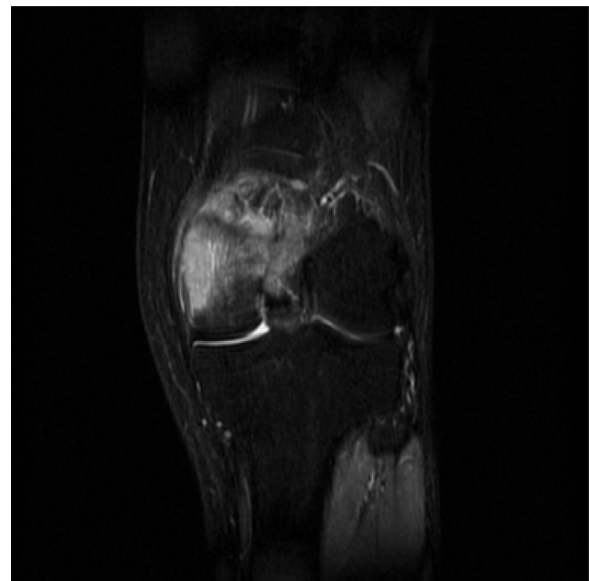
The first MRI of the left knee showing osteomyelitis of the left femur.
